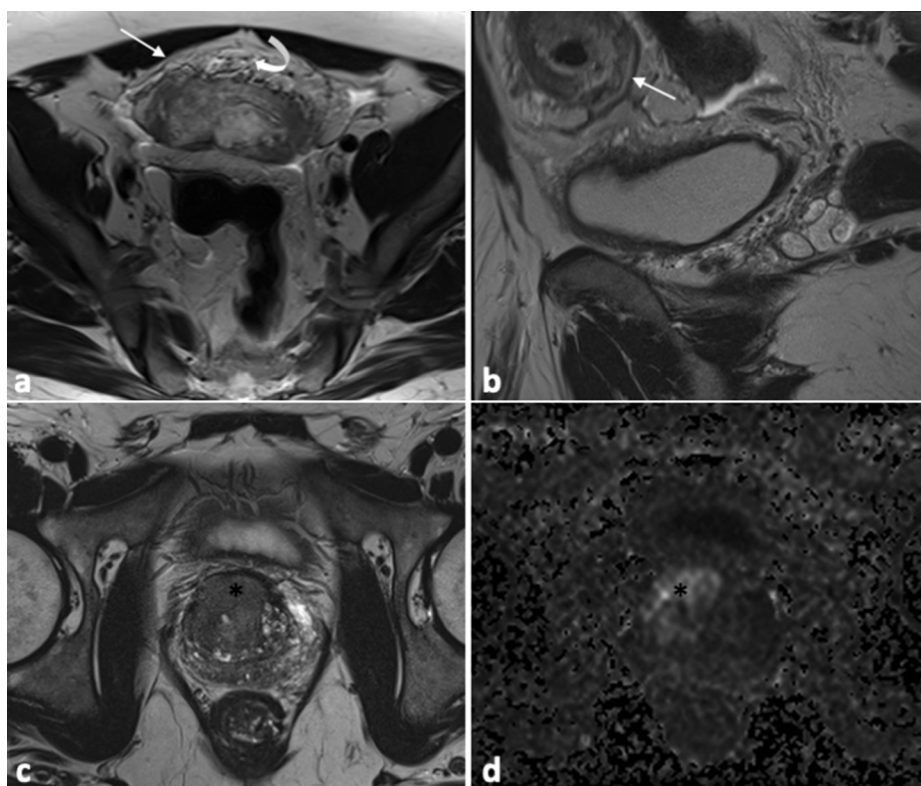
Axial (a) and sagittal T2w (b) images show a sub stenosing sigmoid lesion (arrows) with - fat stranding (curved arrow), pathologically - confirmed after Hartmann's procedure as mucinous carcinoma with traits of signet ring cells. The same patient shows a PI-RADS 5 transitional zone prostatic lesion (asterisks) hypointense on axial T2w image (c) and hyperintense on axial high-b value DWI (d), confirmed at target biopsy as clinically significant prostate cancer (Gleason 8) with aspects of signet ring cells. T2w T2-weighted, DWI diffusion weighted imaging.
